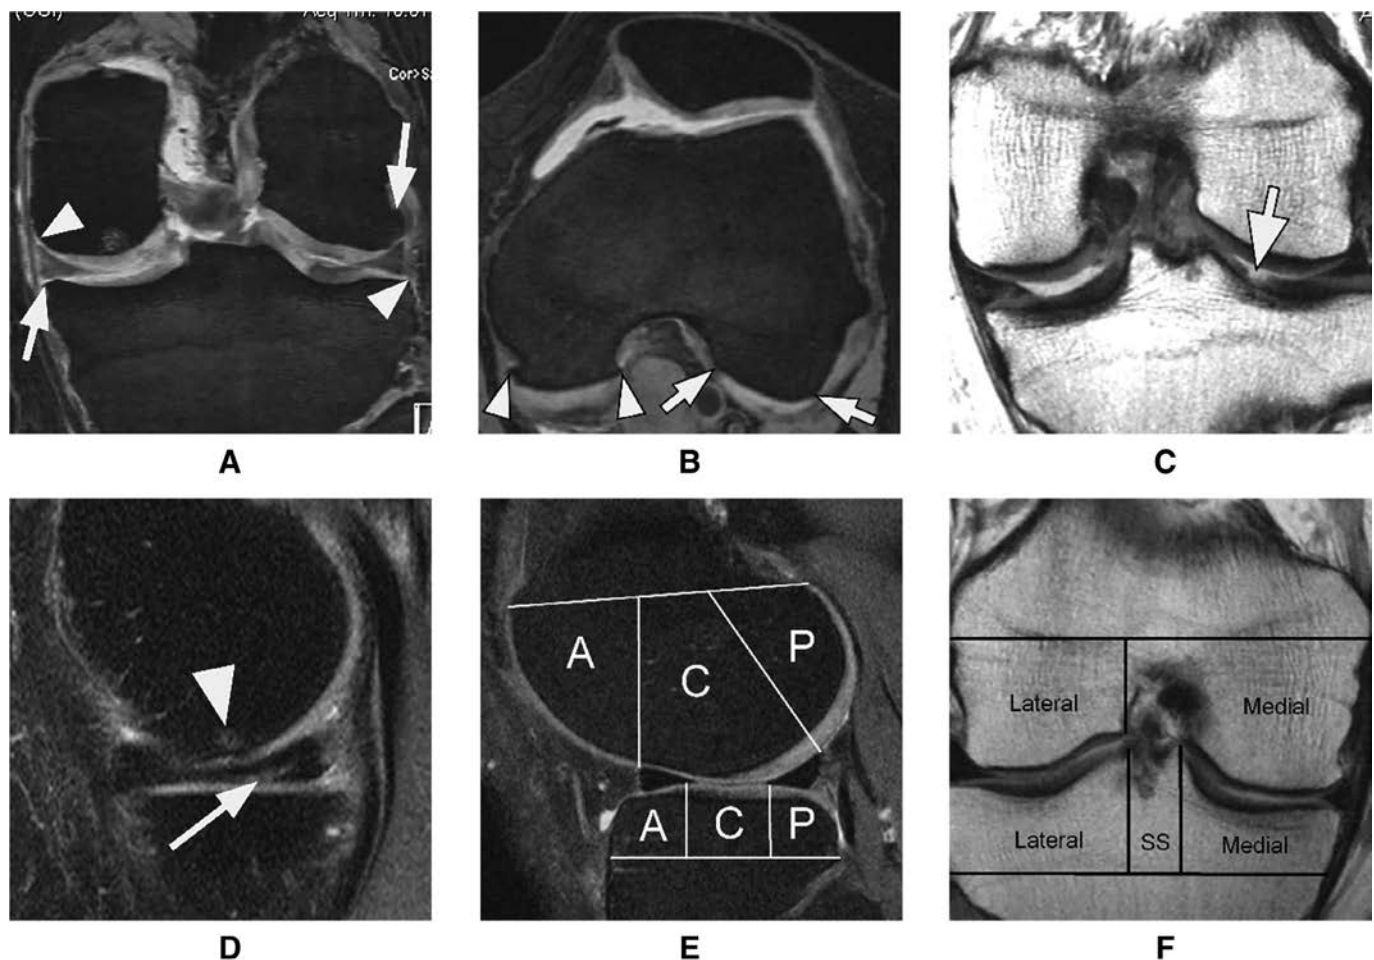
MRI assessment. (A) Osteophytes were considered in this study in six locations based on the MOAKS scoring instrument. Arrows point to small grade 1 osteophytes at the medial tibia and the lateral femur, while arrowheads demarcate the additional two locations that are considered on coronal images (here, coronal reformation of the DESS sequence). (B) Additional two locations considered for the tibiofemoral joint are at the posterior medial (arrowheads) and lateral (arrows) femur. The larger osteophyte at the two possible locations for the medial and lateral posterior femur is considered and recorded. (C) Cartilage damage is scored considering all available sequences. This coronal intermediate-weighted image shows a focal (grade 1.1 in the MOAKS system) full-thickness lesion in the central subregion of the lateral tibia (arrow). Focal lesions do not contribute to joint space narrowing on the anterior-posterior radiograph but are an early feature of OA. (D) Sagittal intermediate-weighted fat suppressed image shows a small subchondral bone marrow lesion (arrowhead) and a posterior horizontal meniscal tear (arrow). (E) MOAKS system subdivides the tibiofemoral joint into 10 distinct subregions. Sagittal image shows the anterior (A), central (C), and posterior (P) subregions for the femur and tibia. Although, for the tibia, all three subregions are considered to be part of the tibiofemoral joint, for the femur only, the central and posterior subregions are considered tibiofemoral, whereas the anterior femoral subregion is considered being part of the patellofemoral joint. (F) Coronal image shows the subdivision into the medial and lateral tibiofemoral compartment, while the SS (subspinous) region is not considered part of the articular tibiofemoral joint but assessed separately as the attachment site for the cruciate ligaments. DESS, dual echo steady state; MOAKS, MRI OA Knee Score; MRI, magnetic resonance imaging; OA, osteoarthritis.
